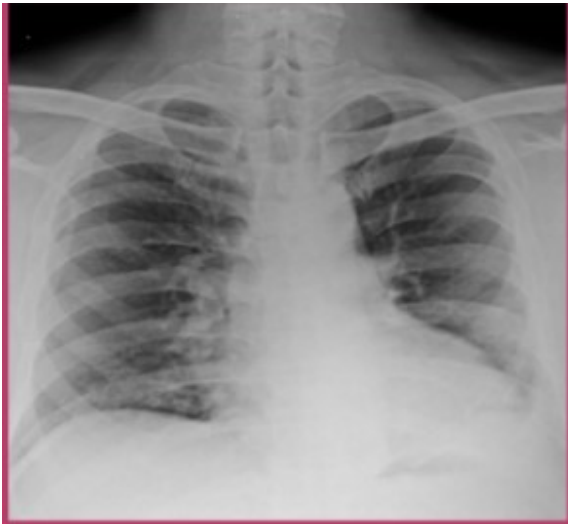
Current chest x-ray
